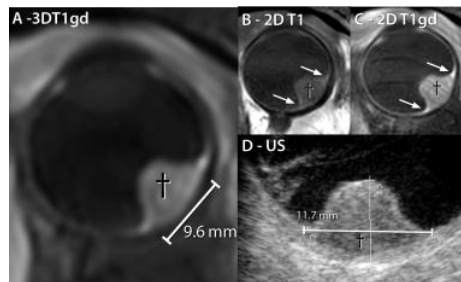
Patient with 2 mm difference in largest basal diameter. On the contrast enhanced 3D T1 (A) a more hyperintense region adjacent to the tumor base was seen, which was more clearly visible on the pre- and postcontrast MS T1 (B,C, arrows). This was considered enhancing choroid and not included in the tumor base for the MRI measurement. This part was, however, included in base for the US measurement (D), resulting in the larger basal diameters.
